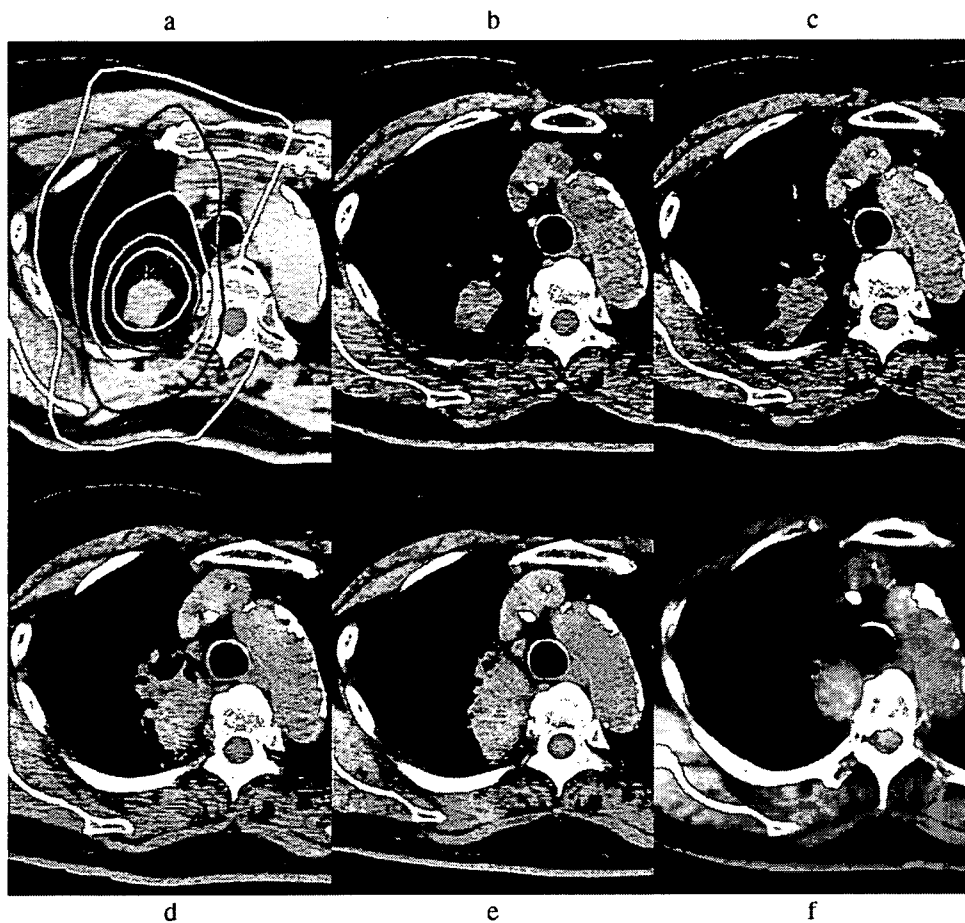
Transverse computed tomography images obtained after hypofractionated stereotactic radiotherapy (HSRT) in an 80-year-old woman with adenocarcinoma of the right upper lobe. (a) Pre-HSRT image with isodose lines. The red line is the 80% isodose curve and corresponds with planning target volume (PTV). (b–f) Images were obtained at 1, 3, 6, 9, and 23 months after completion of HSRT. Solid consolidations gradually enlarged between 3 and 9 months, raising suspicion of local recurrence. However, opacities diminished 23 months after completion of HSRT.
